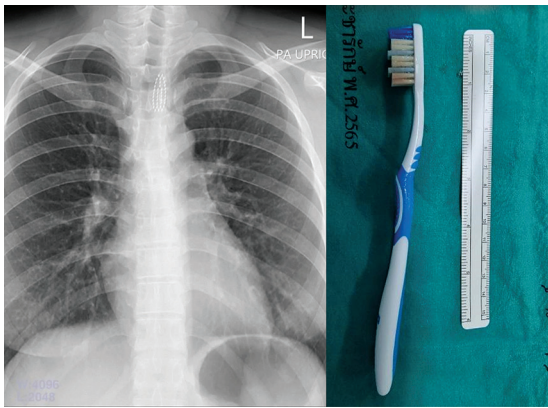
Posteroanterior (PA upright) chest radiograph demonstrating the radiopaque toothbrush bristles within the esophagus.
